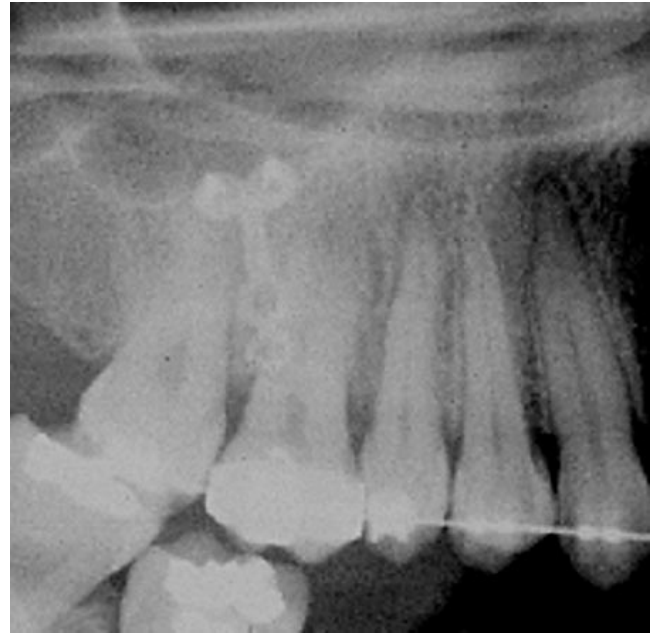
Postintrusion panoramic radiograph of patient 1.
